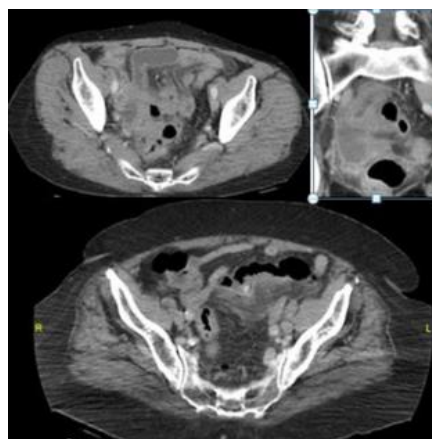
Abdominal CT. 66-year-old- female patient with Hincheys IV. Axial and coronal reformatted images. Phlegmon, purulane mai, pelvic abscess, peritonitis, perforation are observed in the sigmoid colon. Segmental resection was performed and the patient.
